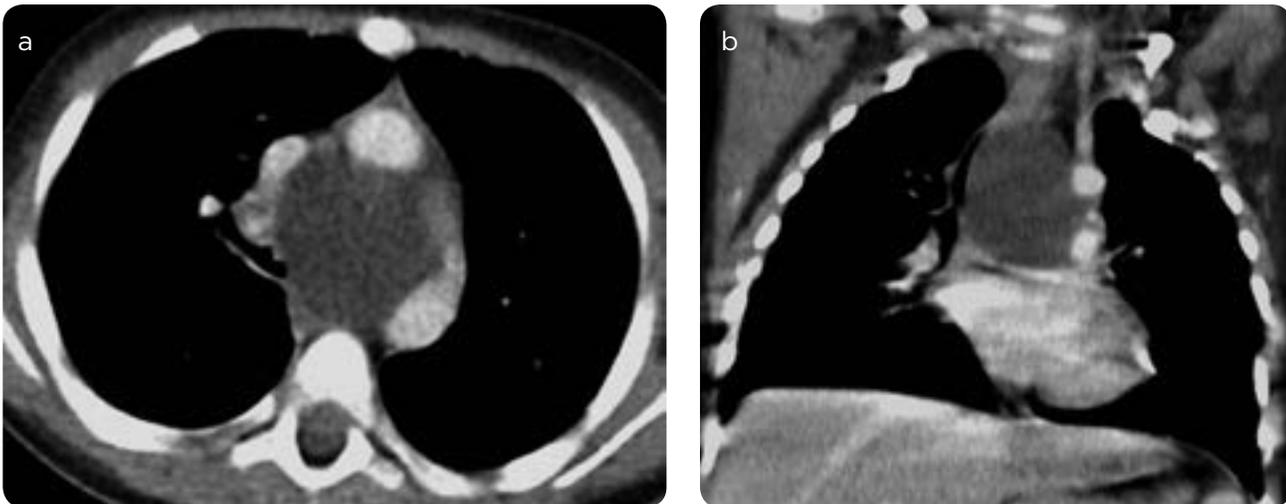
Bronchogenic cyst. 1-year-old girl. a and b) Chest CT, axial and coronal reconstruction in mediastinal window. Subcarinal mediastinal mass, cystic, thin-walled, without enhancement.
